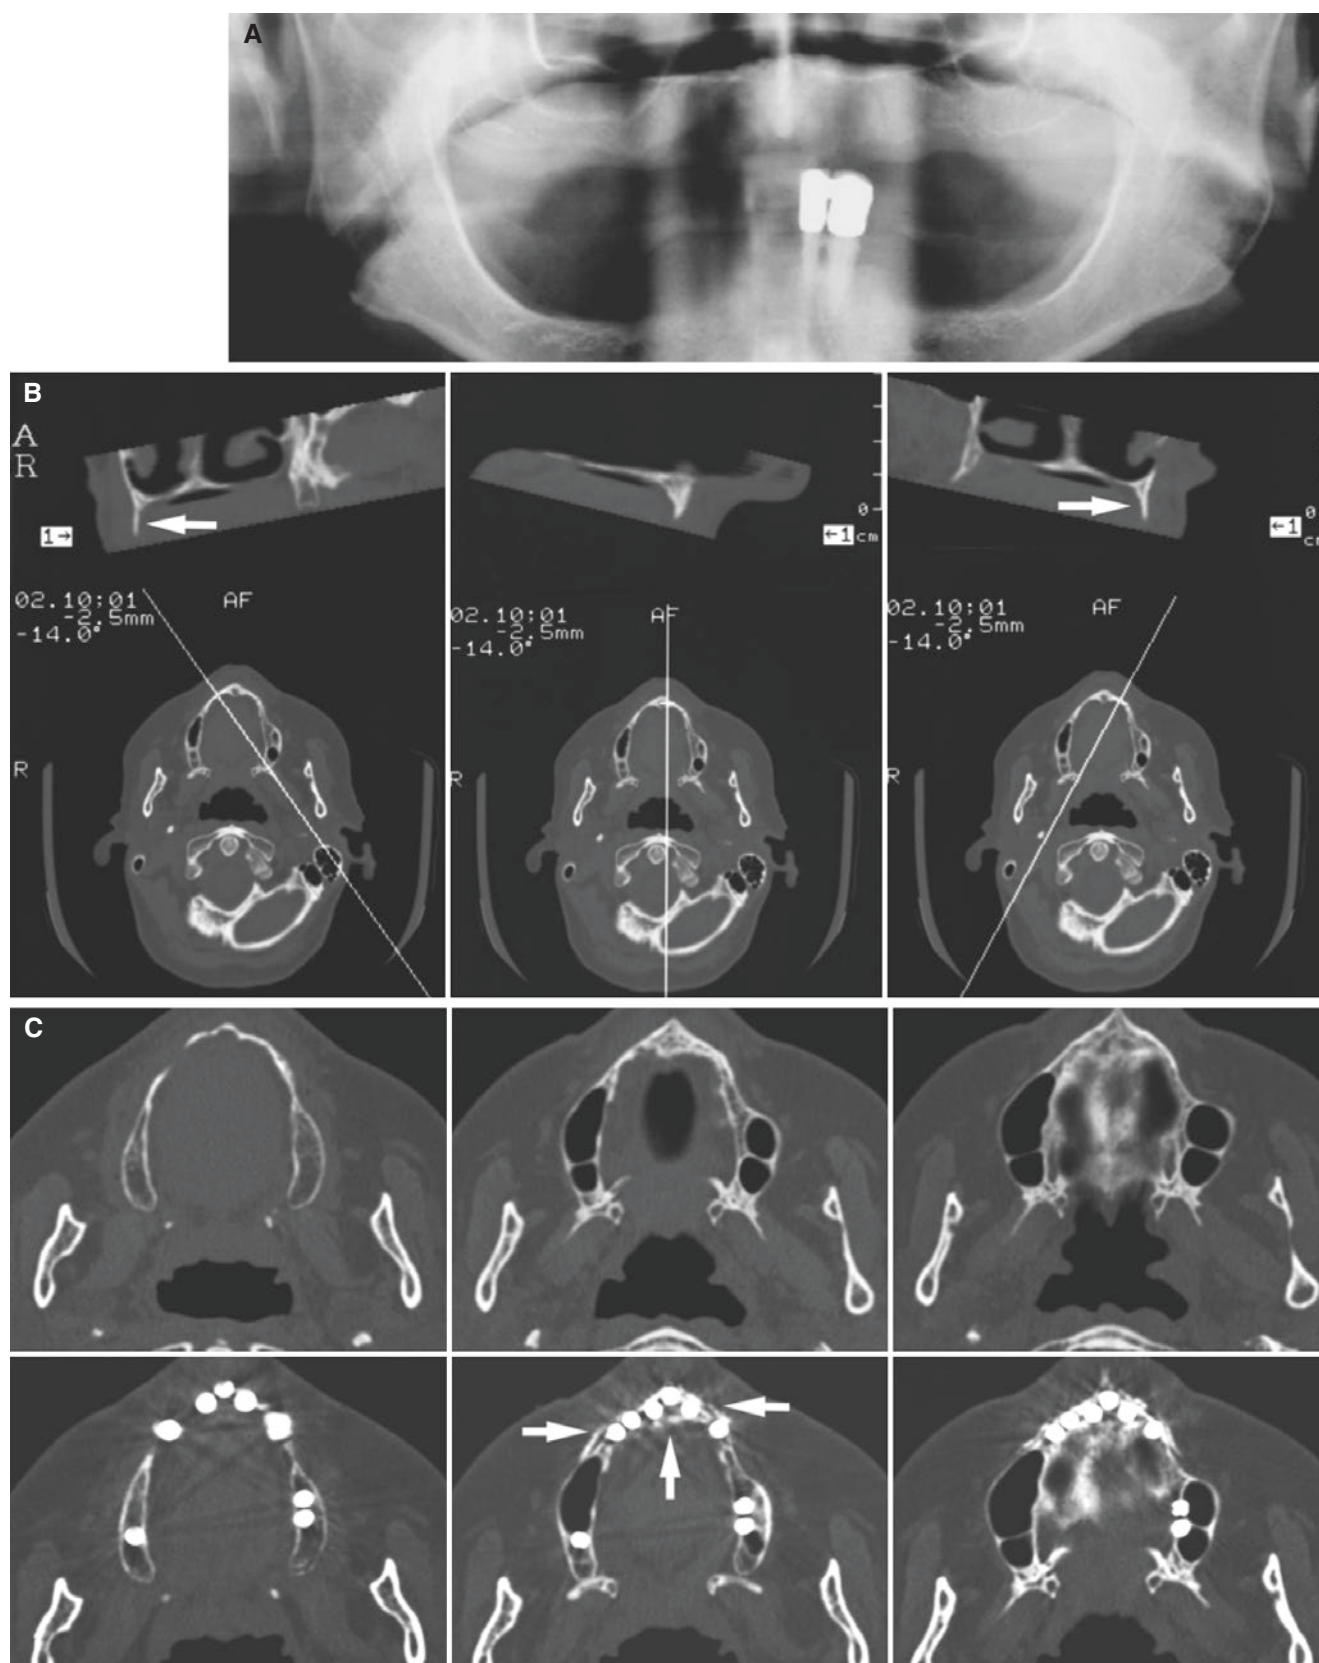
Dental implant surgery with bone graft from the chin; 68-year-old female who could not accept her complete maxillary denture. (A) Panoramic view does not indicate that edentulous maxillary alveolar process is very thin. (B) Three CT sections perpendicular to maxillary alveolar process (according to *cursor lines* in reference
